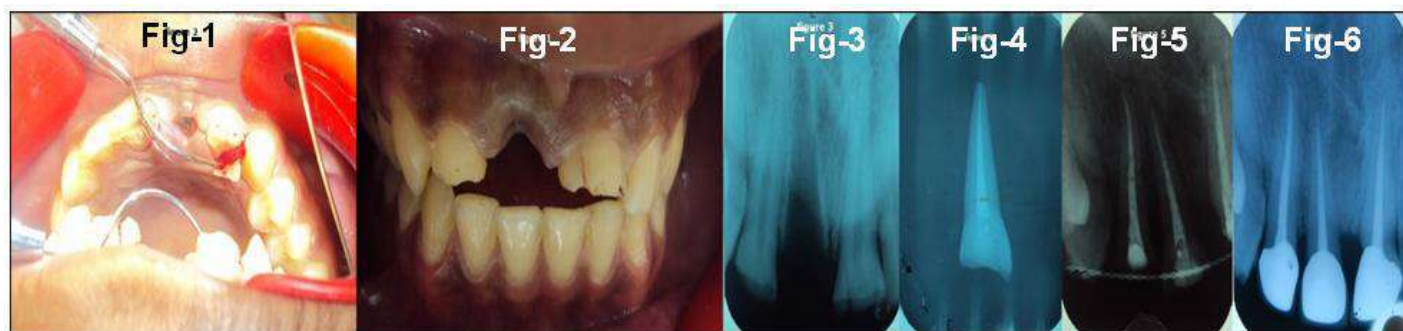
1. Avulsed maxillary right central incisor, Fig: 2. Ellis class III fracture 12, 21, missing 11, Fig: 3. Radiograph showing empty 11 socket, Fig: 4. RCT with 11(extra-oral), Fig: 5. radiograph showing Replanted 11 RCT of 12 21 and splint, Fig: 6. Periodic clinical and radiographic evaluation
